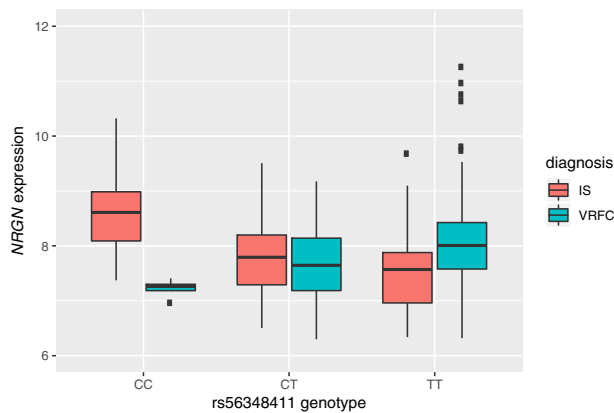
cis*-eQTL rs56348411 for *NRGN*. Linear interaction between genotype (x-axis) of rs56348411 and diagnosis (IS and VRFC) on gene expression of *NRGN* (y-axis). Mean gene expression from the signal space transformation, in conjunction with regular robust multiple-array average normalization method (SST-RMA) (y-axis) with standard error bars are plotted by SNP genotype (x-axis: CC, CT, TT) and diagnosis status (red - IS; green - VRFC). The beta was 0.313, *P* value = 2.10×10^{-8} ; and FDR = 0.088 (Table 2). IS - ischemic stroke. VRFC - vascular risk factor control.
